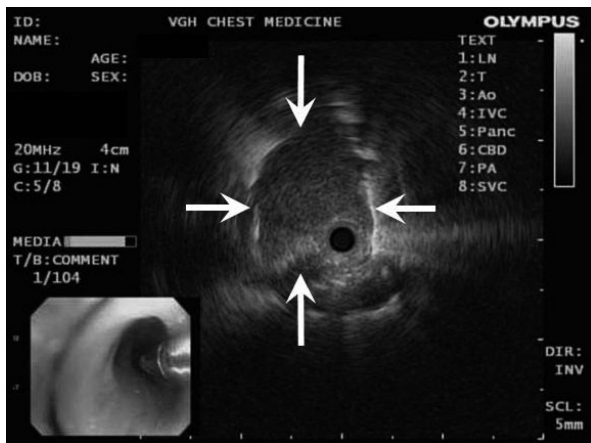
Endobronchial ultrasonography shows a deformable, hypoechoic lesion with pulsation.
